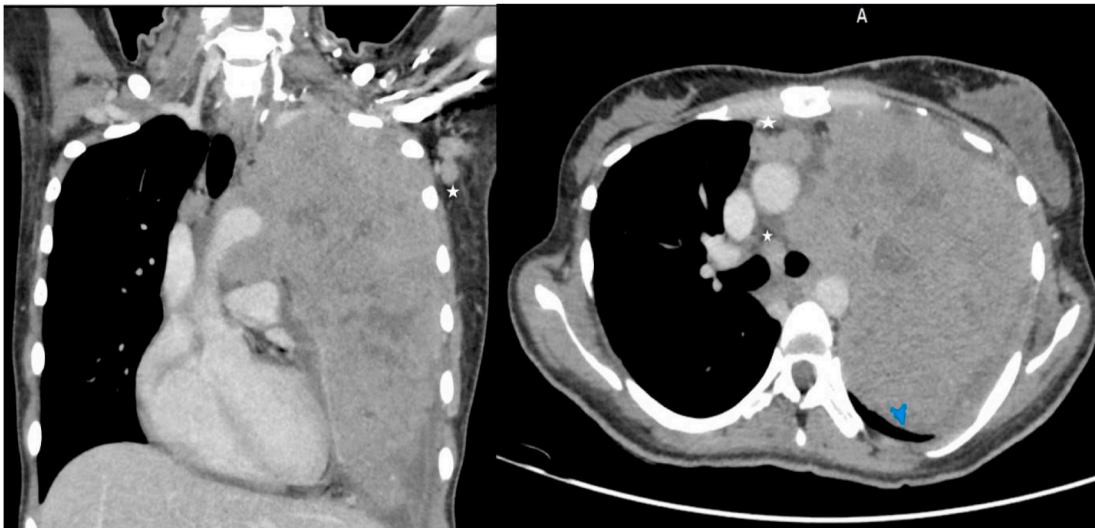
(a, b): Post contrast CT thorax images in coronal and axial sections. Heterogeneously enhancing mass lesion replacing the left lung. A small patch of aerated left lower lobe was noted (blue arrow). Enlarged perivascular, subcarinal and left axillary nodes seen (white stars).
